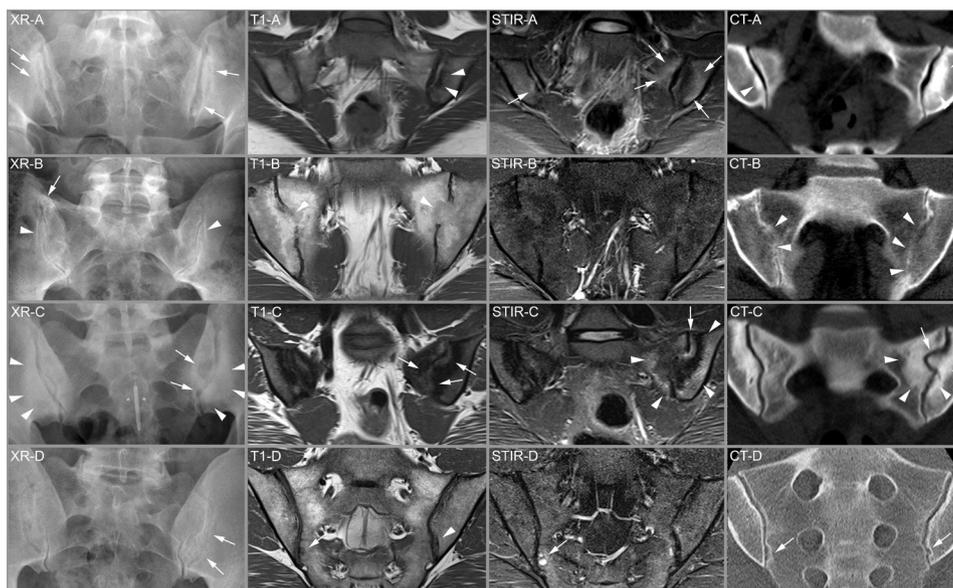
Imaging examples. (A) Female patient with osteitis condensans (23 years old, HLA-B27 negative, normal CRP). Radiography suggests bilateral erosions and joint space blurring (arrows) with mild sclerosis. However, cross-sectional imaging shows no erosions but some bone marrow oedema (arrows) and sclerosis (arrowheads) consistent with the final diagnosis. (B) Male patient with axSpA (53 years old, HLA-B27 positive, long history of back pain). Radiography shows only mild blurring of the joint space (arrowheads) and capsular calcification (arrow) and was deemed negative by all readers. However, MR and CT show extensive ankylosis (arrowheads) with preservation of only a small portion of the joint space, suggesting advanced axSpA. (C) Female patient with mechanical joint disease (34 years old, HLA-B27 negative, normal CRP). Radiography and T1W MR show extensive sclerosis (arrowheads) and irregularities (arrows) on the left side, MR-STIR extensive bone marrow oedema (arrowheads) and joint fluid (arrow). Both were misclassified by the readers as positive for axSpA. In this patient, only CT ruled out erosions (arrow) and confirmed the diagnosis of osteitis condensans and iliosacral complex as an anatomical variant. (D) Male patient with axSpA (40 years old, HLA-B27 positive, normal CRP). Radiography shows only minor irregularities (arrows) and was deemed negative. MR shows small cysts (arrows) and minor irregularities (arrowhead) as well as some bone marrow oedema on STIR but was judged negative by two of the three readers. Only CT shows very tiny erosions, confirming the diagnosis of axSpA (arrows). axSpA, axial spondyloarthritis; CRP, C reactive protein; STIR, short-tau inversion recovery; XR, X-ray.
